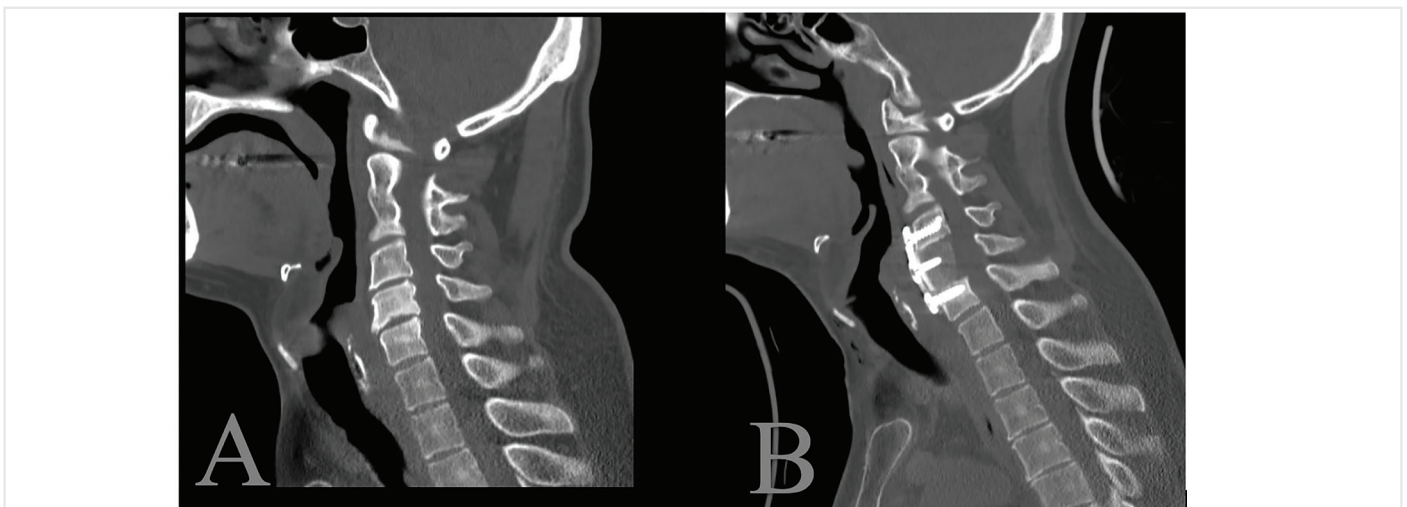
A 37-year-old male patient with C3-5 cervical spinal stenosis reconstructed using an autologous iliac graft (preoperative mJOA score: 13). (A) Preoperative computed tomography (CT) scan revealing multilevel stenosis between C3 and C5. (B) Postoperative CT scan obtained 12 months after C5 corpectomy and iliac graft reconstruction shows proper graft integration and stable cervical alignment (postoperative mJOA score: 18). mJOA: Modified Japanese Orthopaedic Association score
